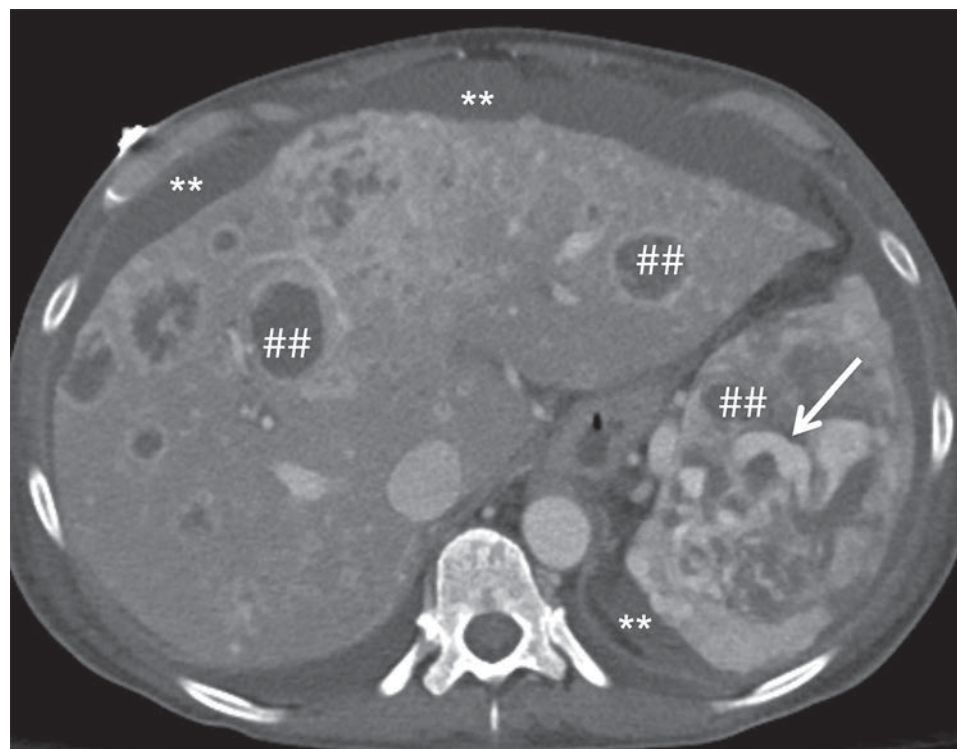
Axial contrast-enhanced CT through the abdomen in a patient with three large hepatocellular adenomas with internal hemorrhage (*) and one with a focus of active bleeding (white arrow).
